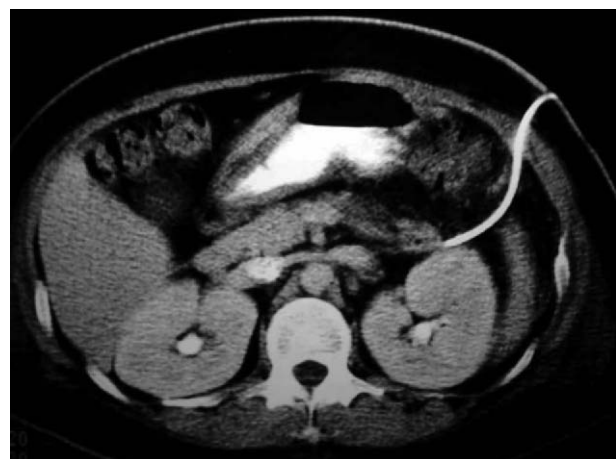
Follow-up abdominal computed tomography shows that the pyelonephritis (acute bacterial nephritis) has resolved and both kidneys are intact, with the percutaneous catheter *in situ* (anterior pararenal space).
